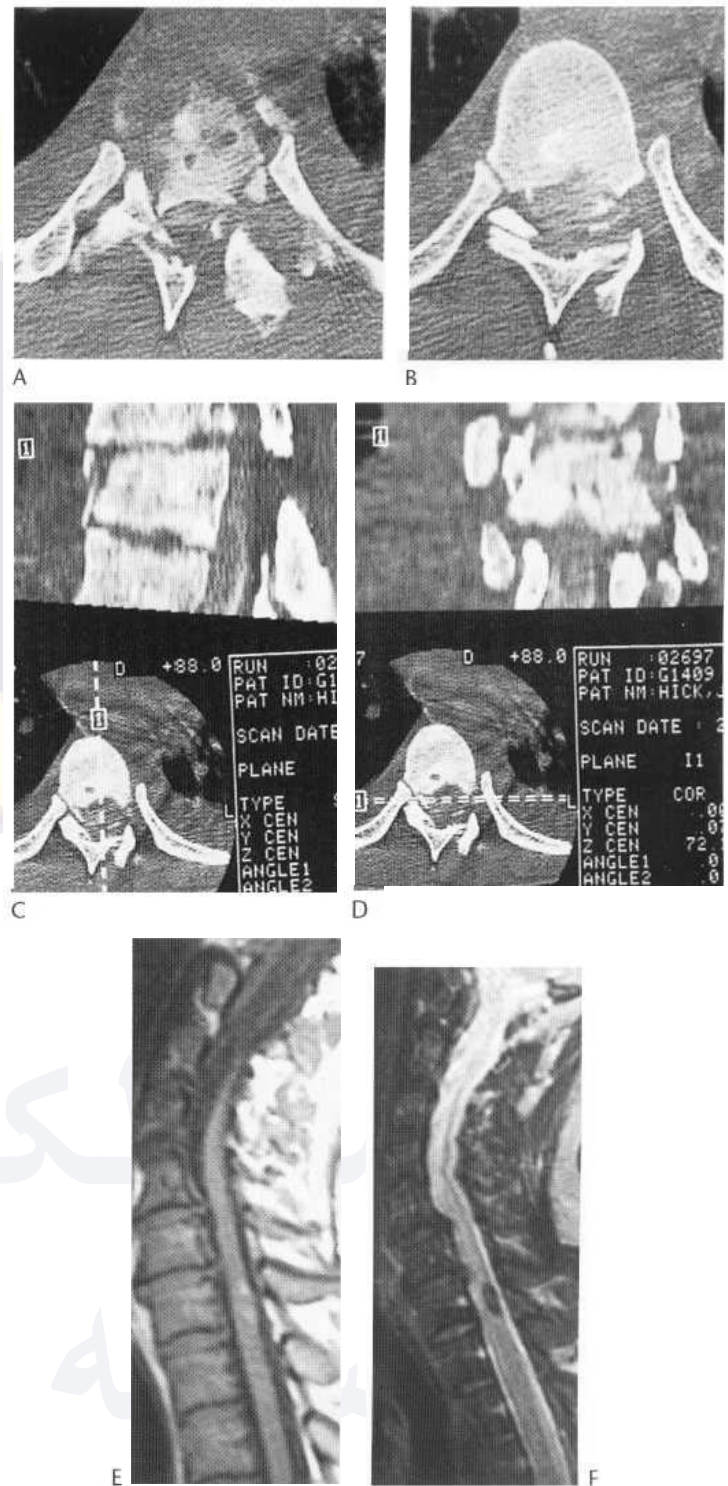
Comminuted fracture of thoracic spine: fractures of the ninth and eighth thoracic vertebrae with anterior subluxation of the eighth. Axial sections through the ninth (A) and the eighth (B) thoracic vertebra, and reformatted sagittal (C) and coronal (D) sections. There is a comminuted fracture with disruption of the body and neural arch of the ninth thoracic vertebra. A fragment has been separated from the posterior inferior margin of the body of the eighth thoracic vertebra and there is anterior subluxation of the rest of the vertebra. The spinal canal is markedly narrowed and the spinal cord is compressed by displaced bone fragments. The subarachnoid space is opacified by a blood clot at T9 and T10 levels. (E,F) MRI of cervical spine. Whiplash injury in road traffic accident 6 months previously. Sagittal sections: T₂-weighted (E); T₁-weighted (F). The spinal canal is narrowed due to spondylosis. A small focus of aging haematoma is shown in the spinal cord at CT, possibly an unrelated cavernoma rather than an evolving haemorrhagic contusion.
